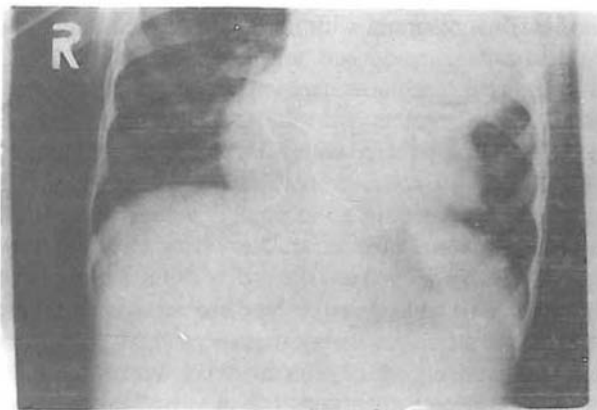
Chest roentgenogram depicting a huge mass occupying the entire left upper hemithorax.
